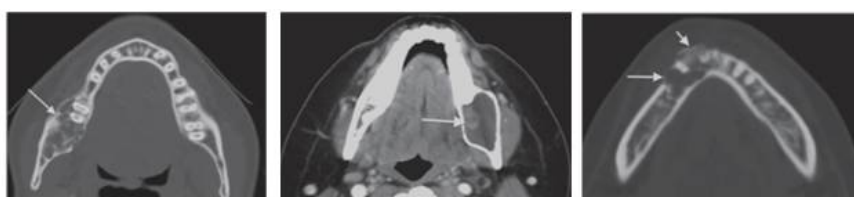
Ameloblastoma. (A) Axial bone CT shows the multi-septated or loculated appearance of the multicystic ameloblastoma. Also, it shows coarse septations and the eccentric expansion (arrow). (B) Axial contrast-enhanced CT of a unicystic ameloblastoma demonstrates a cystic lesion eccentrically expanding the buccal and lingual cortices. The enhancing mural nodule (arrow) is a characteristic feature for ameloblastoma. (C) Axial bone CT of a desmoplastic type of ameloblastoma. The expansile lobulated and loculated mass (long arrow) is characteristic for ameloblastoma; the more anterior location is less common. However, the location, aggressive sclerotic changes and periosteal reaction (short arrow) are seen more often in this type.
